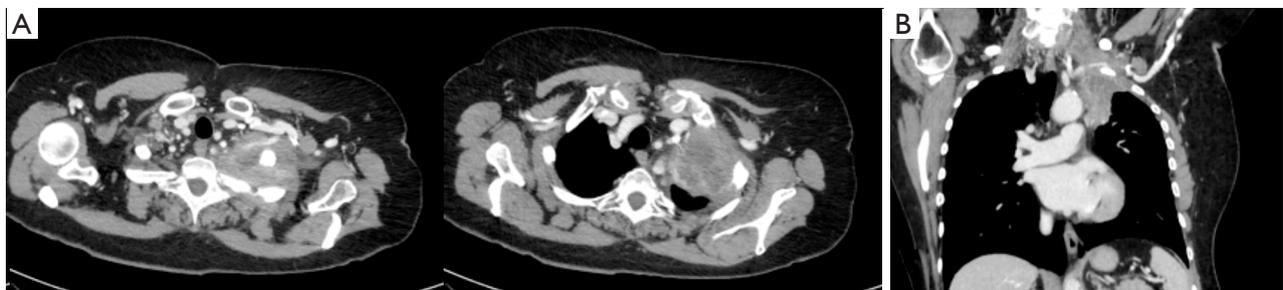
Pancoast tumor. Axial (A) and coronal (B) computed tomography scans reveal a superior sulcus tumor invading the ipsilateral subclavian artery.
